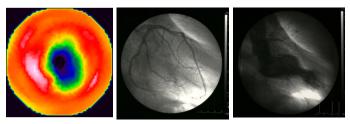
Myocardial SPECT after 30min with ^{99m}Tc-MIBI IV and CAG and LVG [Result] Takotsubo Cardiomyopathy.
